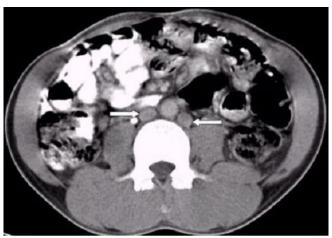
Contrast enhanced CT image in the portal venous phase showing two venous channels adjacent the aortaduplication of inferior vena cava (white arrows).
